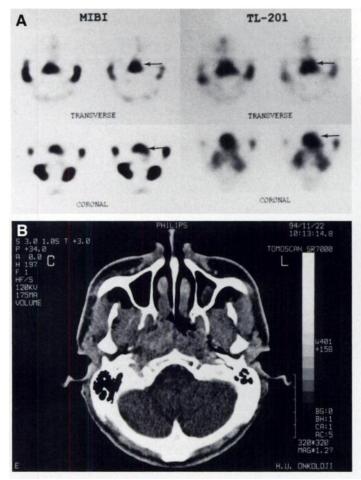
(A) Transverse (upper panels) and coronal slices (lower panels) of MIBI and <sup>201</sup>TI SPECT studies, respectively, reveal intense radiotracer uptake in the region of nasopharynx (arrows) consistent with a malignant process. (B) CT study of the nasopharynx demonstrates a mass obliterating the pharyngeal recesses, bilaterally, and extending anteriorly towards the nasal cavity consistent with NPC.
